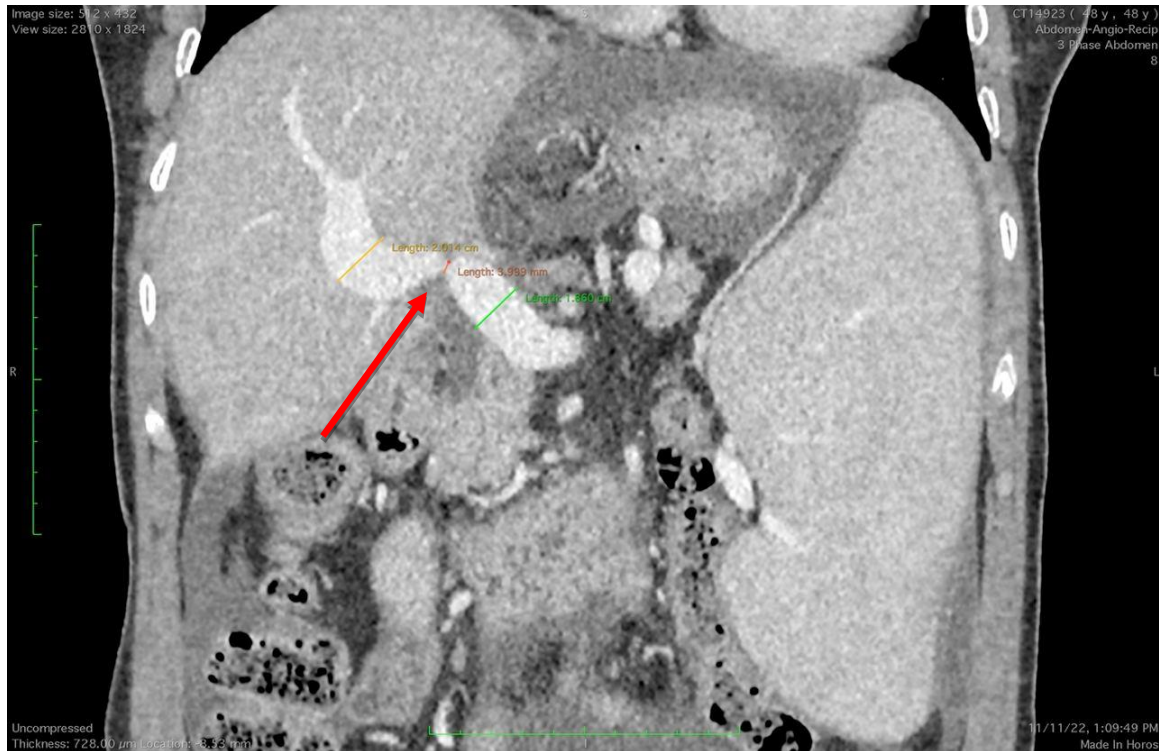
CT-angiography. The arrow indicates the site of portal vein stenosis. PVS diameter was 3.9 mm.
